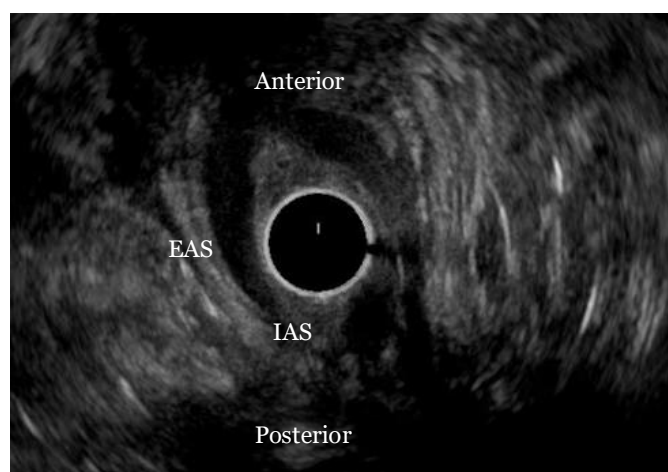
Endoanal ultrasound image showing a posterior defect of IAS and both thinning and scarring of EAS
